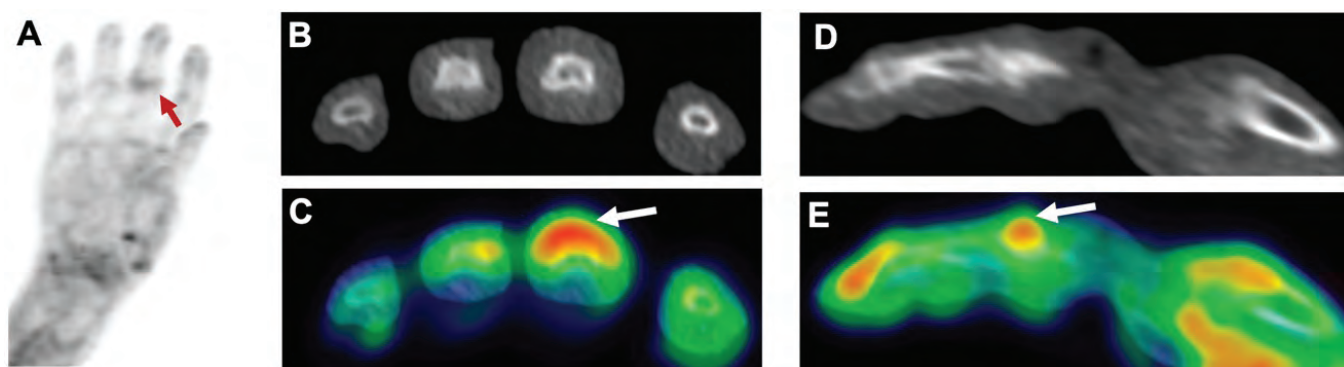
Enthesitis on PET/CT in PsA: Extensor digitorum tendon uptake at the central slip, showing enthesitis; (A) Maximum-intensity projection through the PET scan of the right hand of a participant with PsA showing enthesial uptake at the third PIP joint; axial (B) and sagittal (D) sections through the CT scan of the third PIP joint (grayscale); and axial (C) and sagittal (E) section from the overlay of PET (color) on CT (grayscale).
